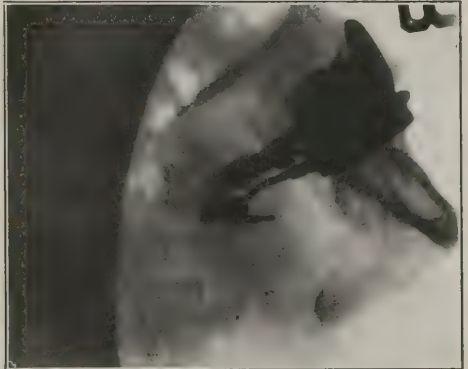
Case 4: Radiograph taken two months after operation, showing outlines of grafts.
